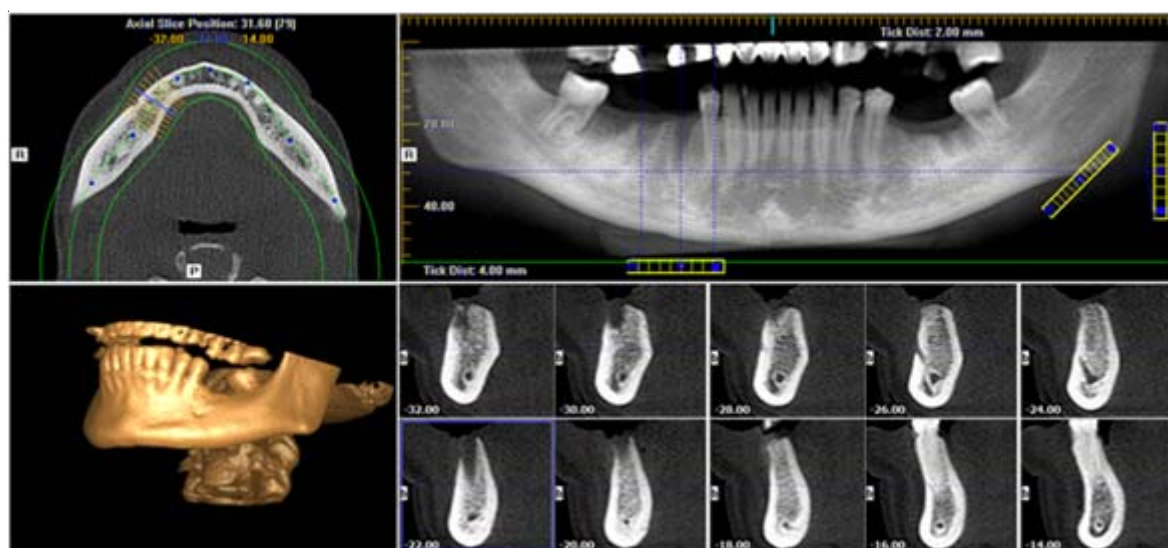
CBCT images reconstructed into multiple-plane views (axial, sagittal, coronal, and panoramic) and three-dimensional representations
